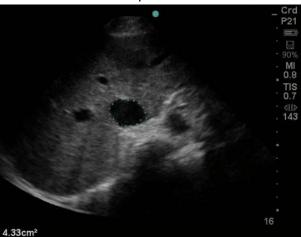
Ultrasound images of a 39-year-old pregnant woman
